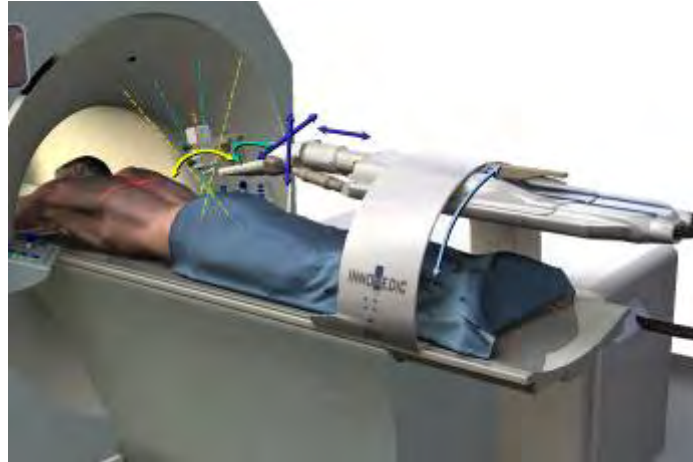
INNOMOTION with six degrees of freedom can be mounted on different types of MRI patient beds
